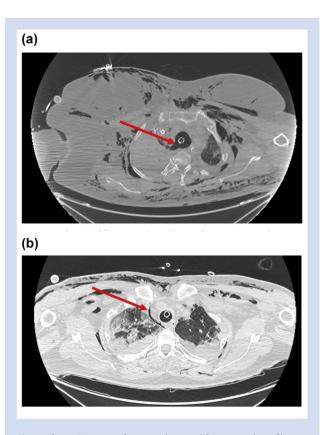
Chest CT scan of two patients with coronavirus disease 2019 (COVID-19) showing pneumomediastinum, subcutaneous emphysema, and pneumothorax. (a) Pneumomediastinum following tracheal trauma. The continuum between the trachea and the mediastinum is represented by a red arrow. (b) Pneumomediastinum after cricoid membrane perforation. Pneumomediastinum is represented by a red arrow. normoxaemia with a Pao₂ of 19 kPa (oxygen by mask at 6 L min^{-1}), HCO₃⁻ of 26.5 mM, Paco₂ of 4 kPa, and pH 7.4. RT–PCR of nasopharyngeal swabs was positive for SARS-CoV-2. On Day 3 after admission, the patient worsened with acute respiratory failure and oxygen desaturation to 90% with oxygen by mask (9 L min⁻¹). To provide mechanical ventilation and correct hypoxaemia, tracheal intubation was attempted. The first attempt showed a Grade IV view on laryngoscopy requiring use of a bougie (Eschmann introducer, Vygon 15Fr, Vygon) and was unsuccessful. On the second attempt, successful tracheal intubation was performed using videolaryngoscopy (Airtraq®; Prodol Meditec, Guecho, Spain). As the patient presented criteria of severe ARDS according to the Berlin classification,³ and required protective ventilation with high PEEP (13 cm H_2O , 6 ml kg⁻¹ of ideal body weight) and high inspired oxygen fraction (100%). Despite early prone positioning, the patient developed refractory hypoxaemia and respiratory acidosis (pH 7.22) requiring veno-venous femoro-jugular ECMO and was transferred to our tertiary hospital centre. Chest CT confirmed pneumomediastinum and bilateral pneumothorax (Fig 1b). Fibreoptic bronchoscopy confirmed perforation of the cricoid membrane. Ventilation was possible without cutaneous emphysema or tidal volume loss.
